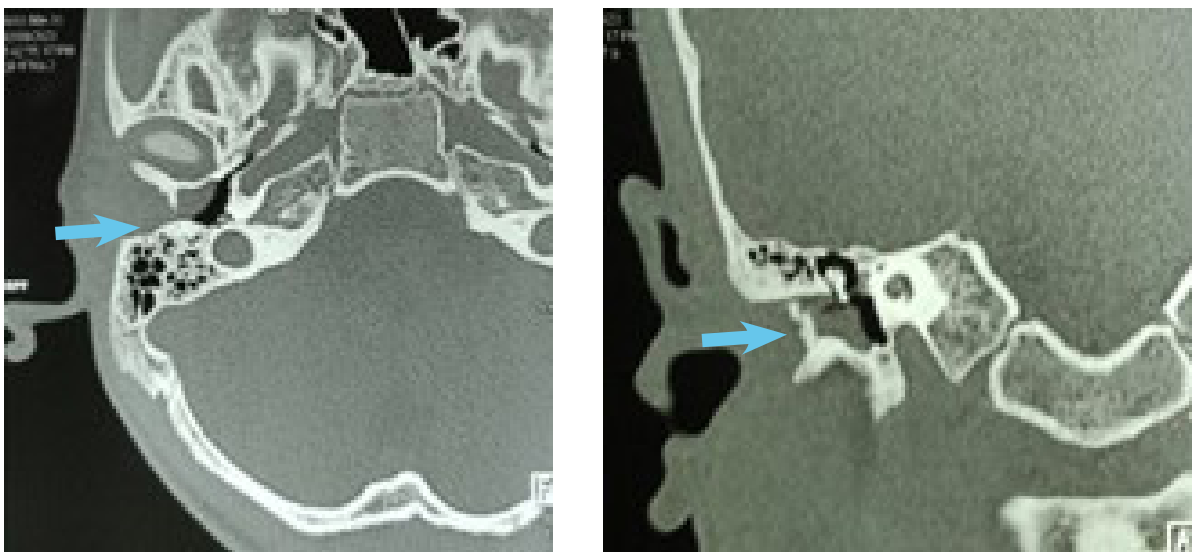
Axial and coronal films of HRCT temporal bone showing soft tissue density in Right External Auditory Canal (blue arrow)
